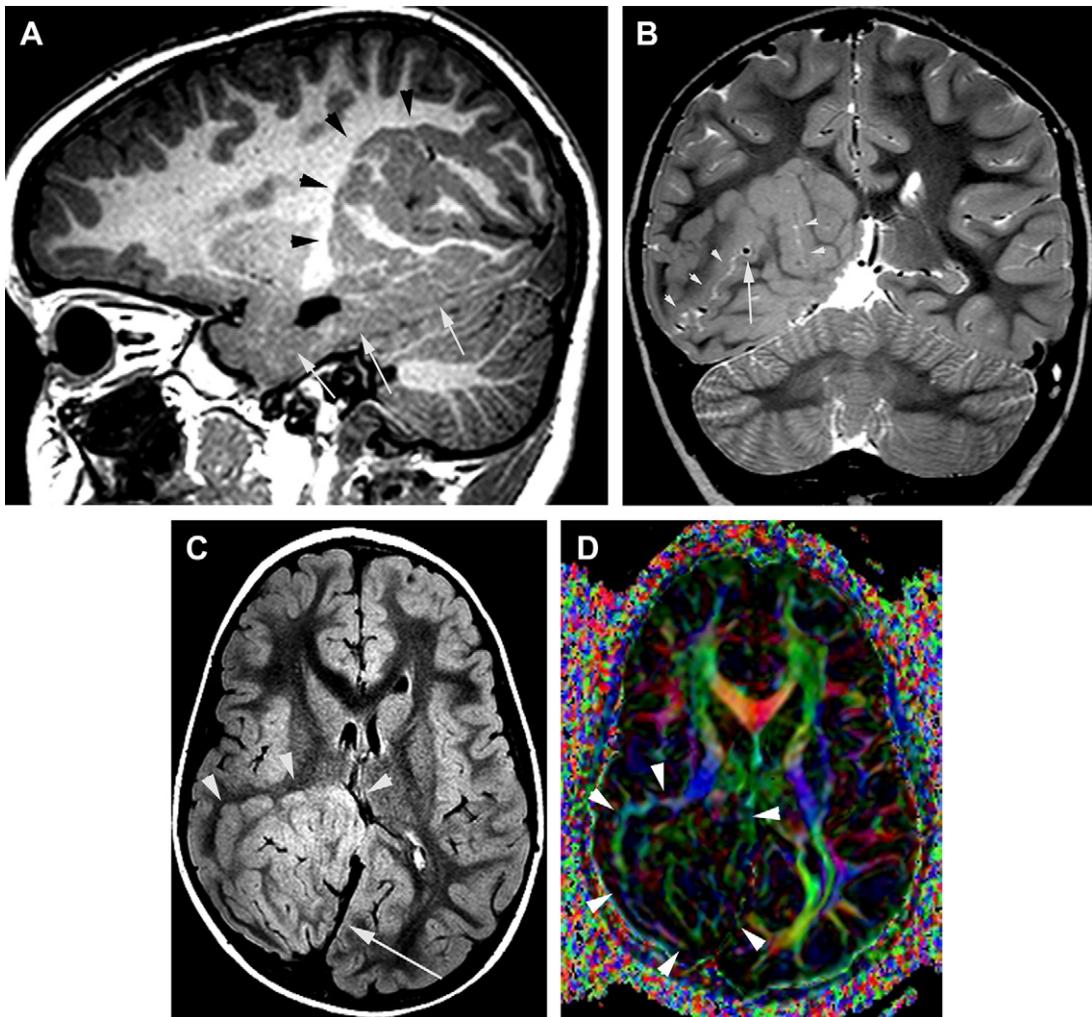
Subcortical nodular heterotopia. (A) Lateral sagittal T1. Large nodular conglomerate of intermingled gray and white matter (*black arrowheads*); the malformation extends along the inferior aspect of the temporal lobe (*arrows*). (B) Coronal T2. Besides cortical-like gray matter and the associated white matter, the malformation presents with a deep CSF-containing and vessel-containing fissure (*arrowheads*). (C) Axial FLAIR. Despite its volume, the SCNH (*arrowheads*) is associated with focal hypoplasia of the hemisphere with dislocated falx (*arrow*). (D) FA color mapping. The hemispheric white matter fascicles are disorganized at the level of the SCNH (*arrowheads*), but within the heterotopia, the white matter appears organized in a coherent fashion (appearing mostly *green*—dorsoventral, or *blue*—craniocaudal, in this image).
